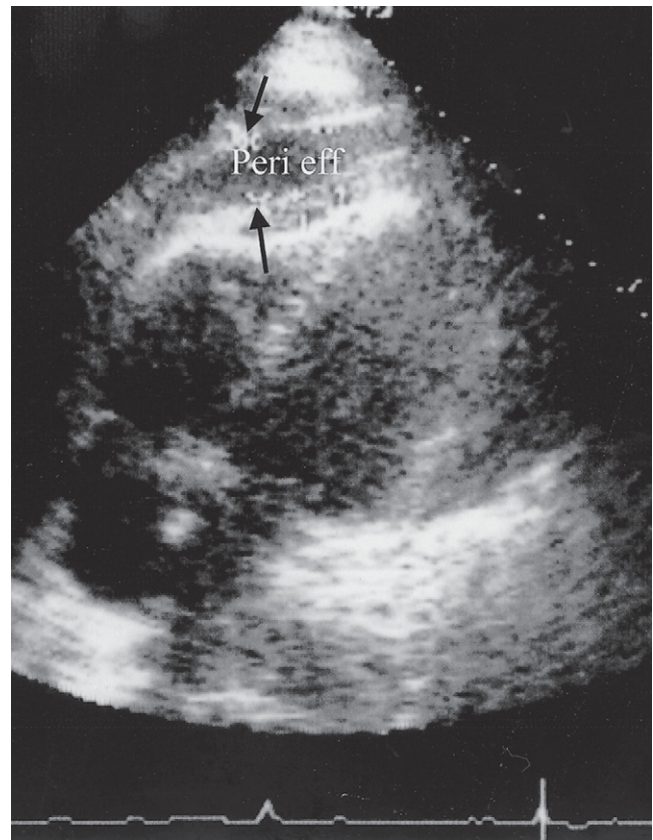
Two-dimensional echocardiographic image of an acute pericardial effusion (Peri eff) complicating percutaneous transluminal myocardial revascularization. Localization of a loculated collection of fluid is used to direct needle pericardiocentesis.
